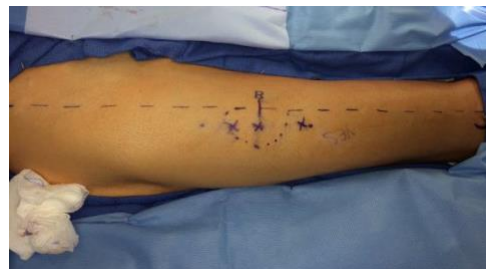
Dopplered mapped perforators (79).
